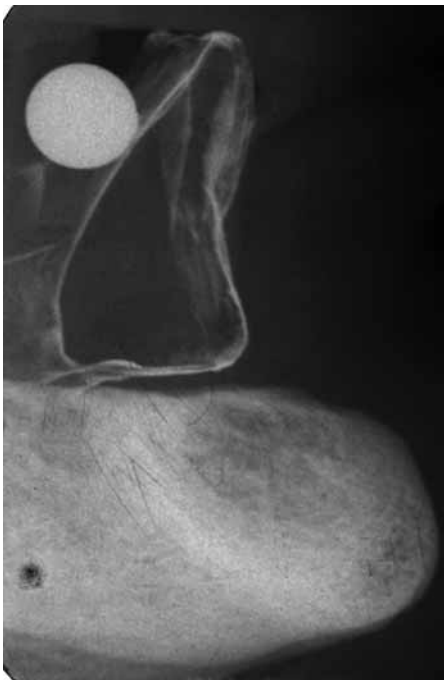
This radiograph demonstrates that adequate implant orientation would be impossible with a denture in the present position.
